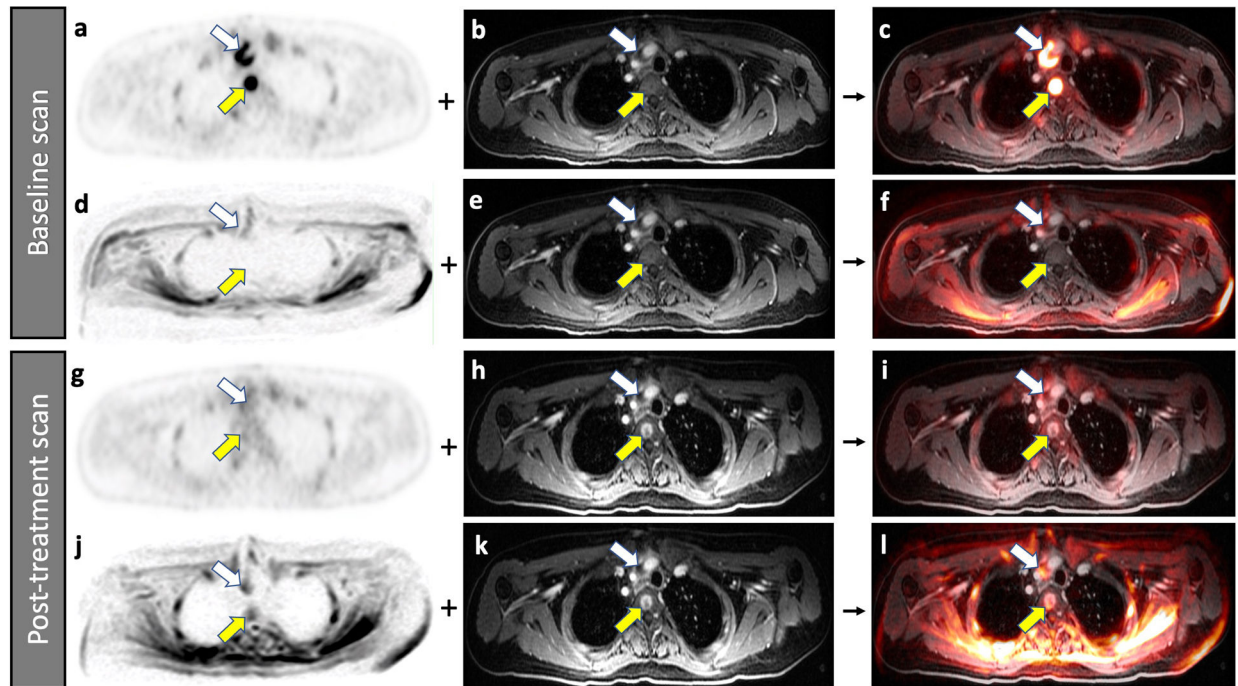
Abbreviations: PET/MR: positron emission tomography/magnetic resonance, 2-[<sup>18</sup>F]FDG-PET: 2-[<sup>18</sup>F]fluoro-2-deoxy-D-glucose enhanced positron emission tomography, DW-MRI: Diffusion weighted-magnetic resonance imaging.
